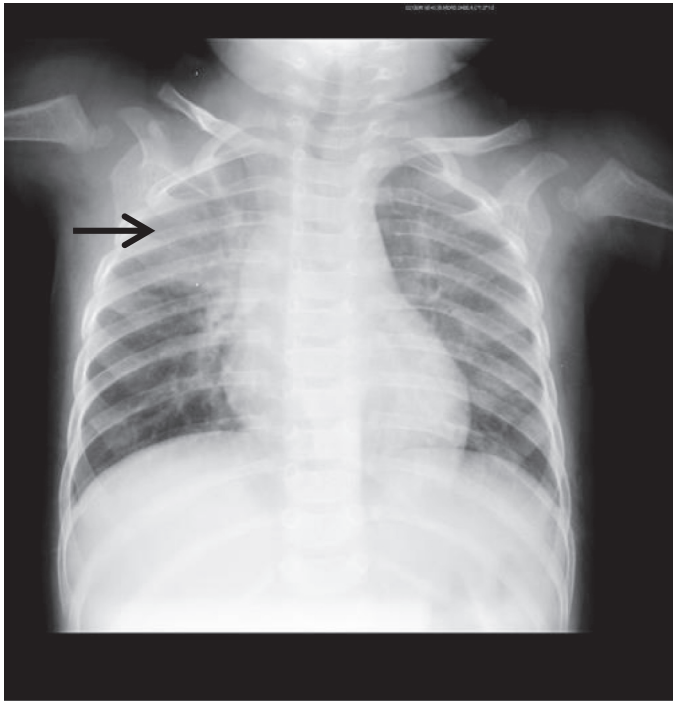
Antero-posterior chest x-ray of the index patient, aged 7 weeks. Note right upper lobe opacities as a sign of aspiration pneumonia (arrow).
